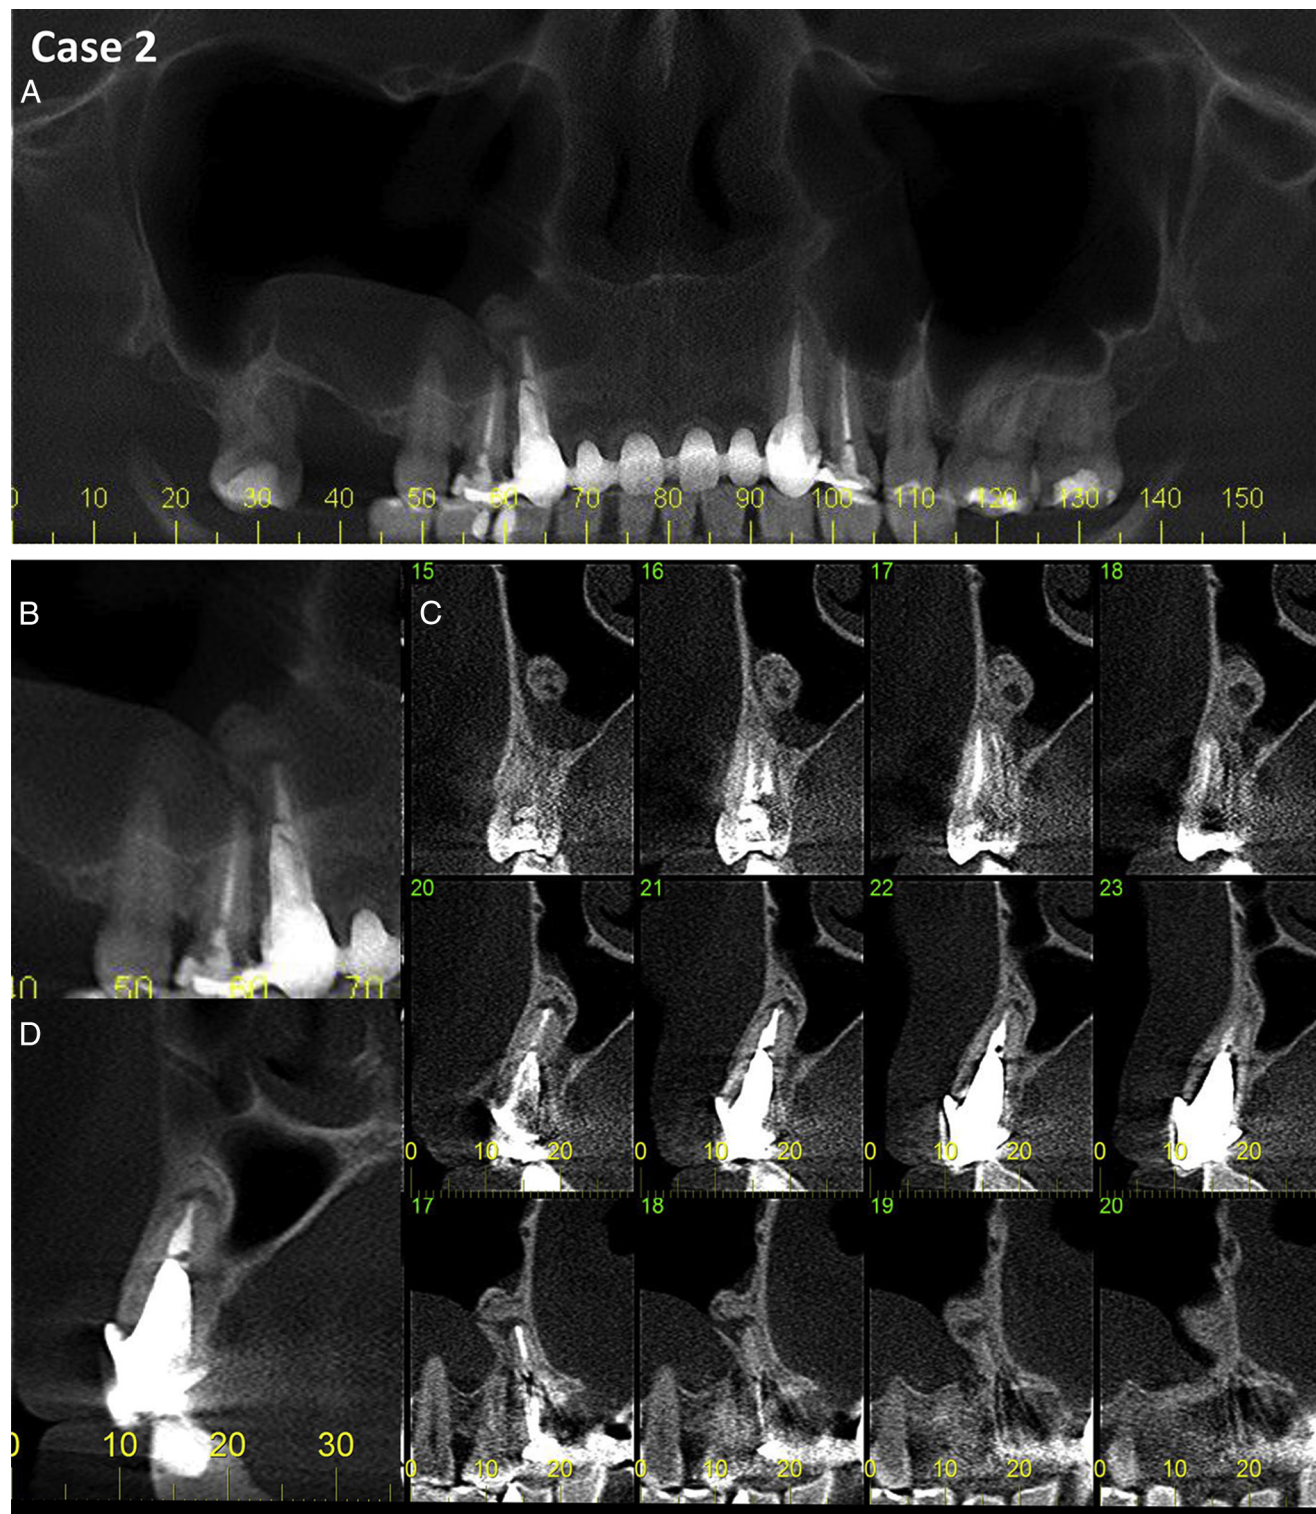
(A–D) CBCT scan of tooth #6 shows a circumscribed hypodense periapical lesion projecting into the right MS. (B–D) Heterogeneous hyperdense oval structure associated with tooth #6 contains irregular mixed contents. (A and B) Mucous retention cyst adjacent to maxillary bone formation in the right MS.
